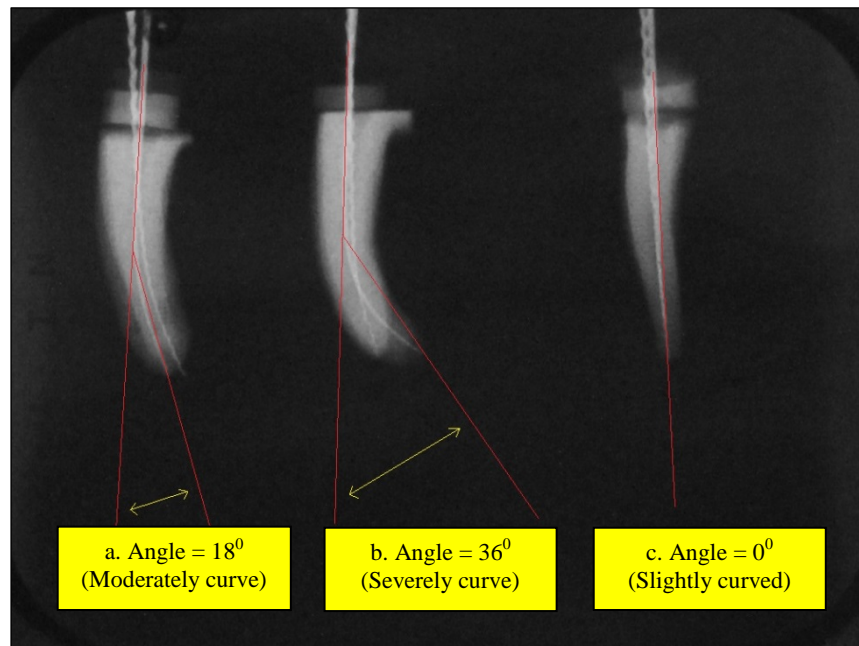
Radiographic image showing three mandibular molar mesial roots, each with a size 15 K-file and Hedstrom file in separate canals.
